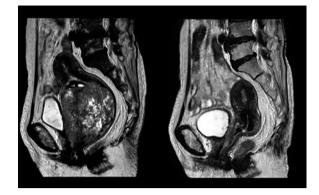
A 74-year-old female with stage IIIB squamous cell carcinoma of the cervix. MRI taken before treatment reveals bulky cervical tumor in the pelvis (*left*). She received CIRT consisting of 72.0 GyE in 20 fractions over 5 weeks. Neither brachytherapy nor concurrent chemotherapy was given. At the end of CIRT, the cervical tumor had disappeared completely (*right*). The patient has remained free of disease and any radiation-related treatment complications over 4 years after treatment. Dose distribution of the treatment plan is shown in Fig. 15.3
